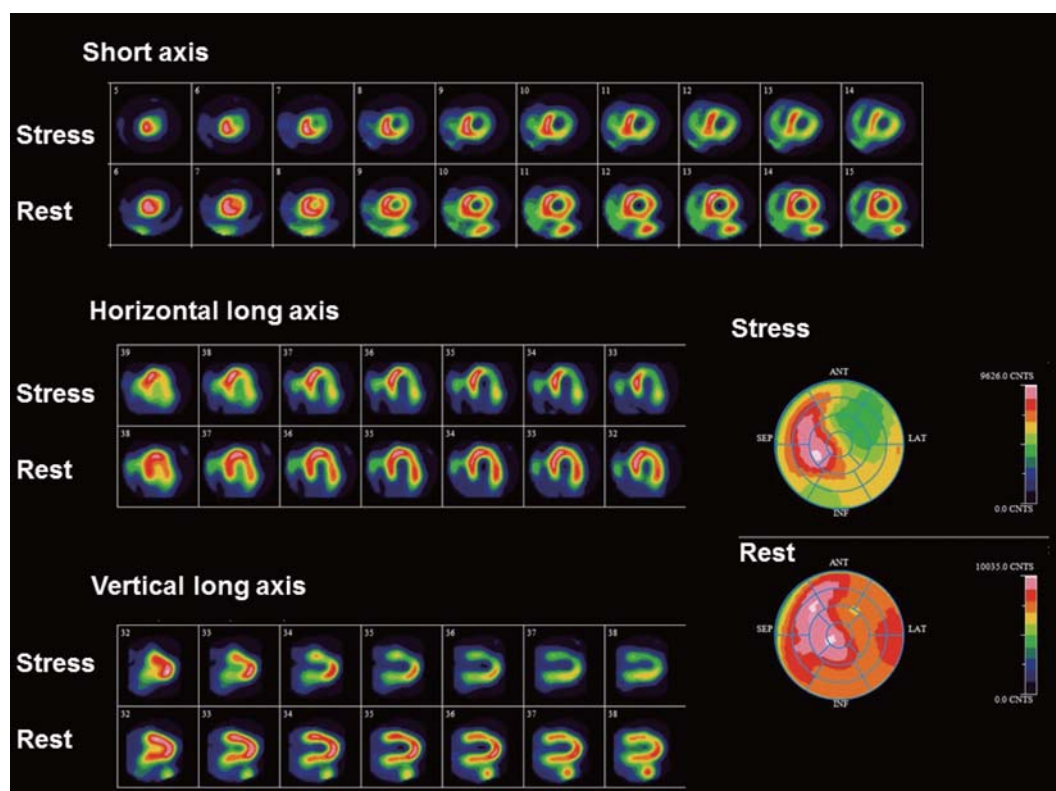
A representative case with pharmacological SPECT-MPI
